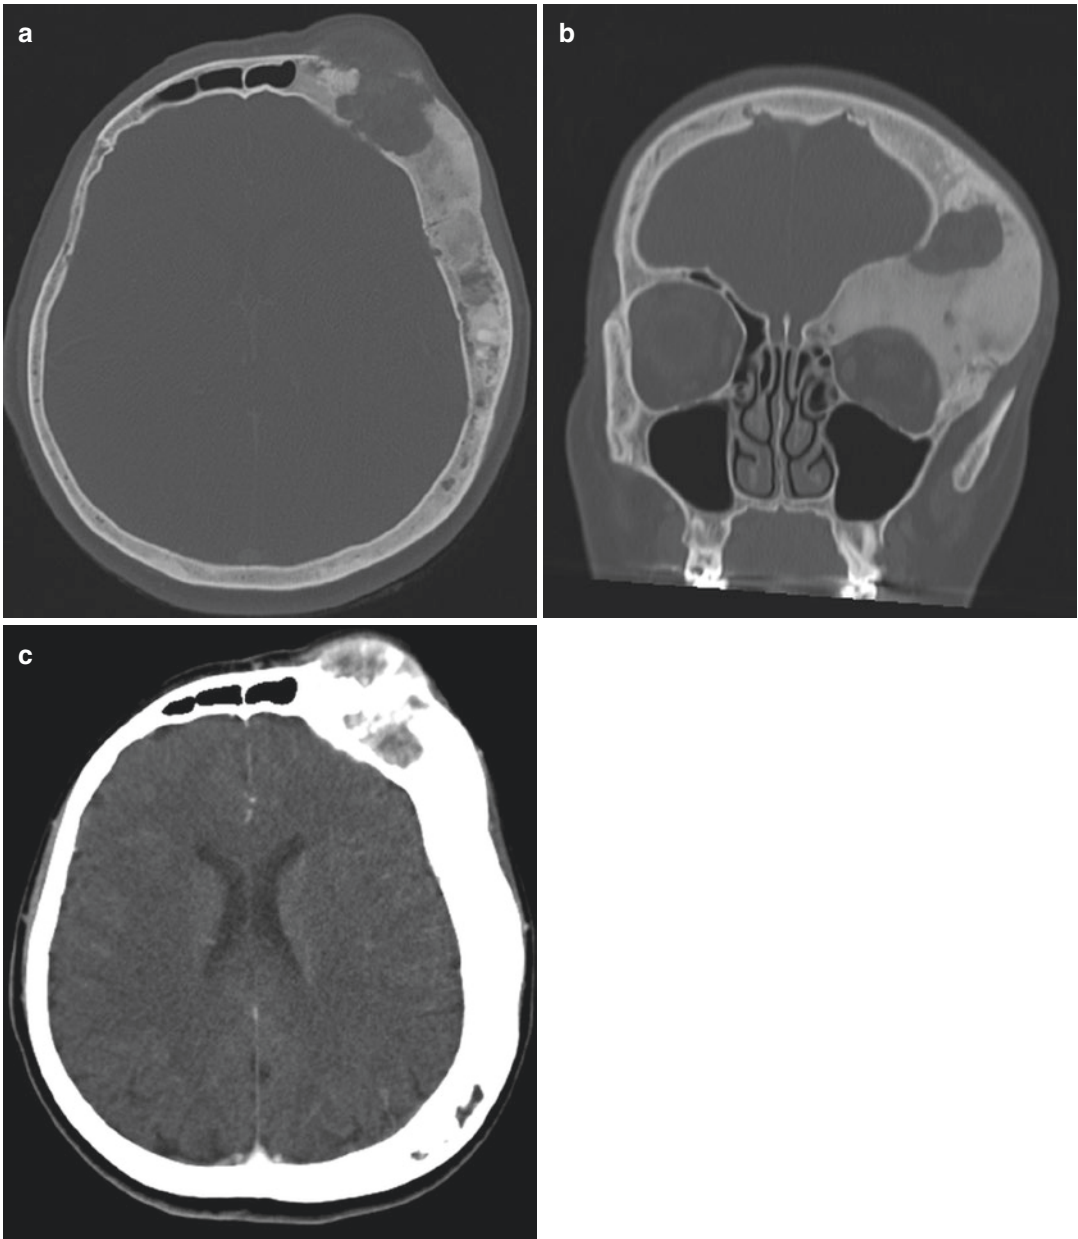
Contrast-enhanced follow-up CT images of the head—note the left frontal bone defect (a, b) caused by an irregularly enhancing (c) osteolytic expansile lesion, not evident in Fig. 16.1
